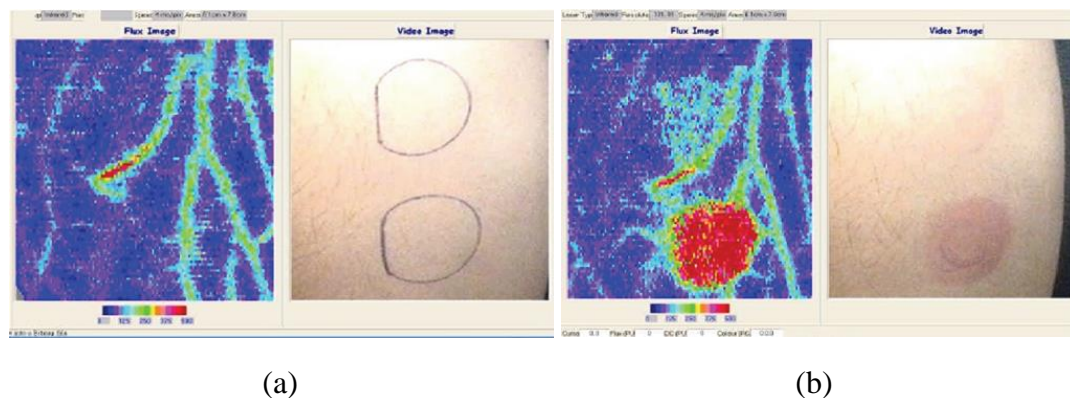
Laser Doppler imager (LDI) captured images for (a) human skin before applying two different doses of UVB irradiation, and (b) after erythema was induced. [107]
